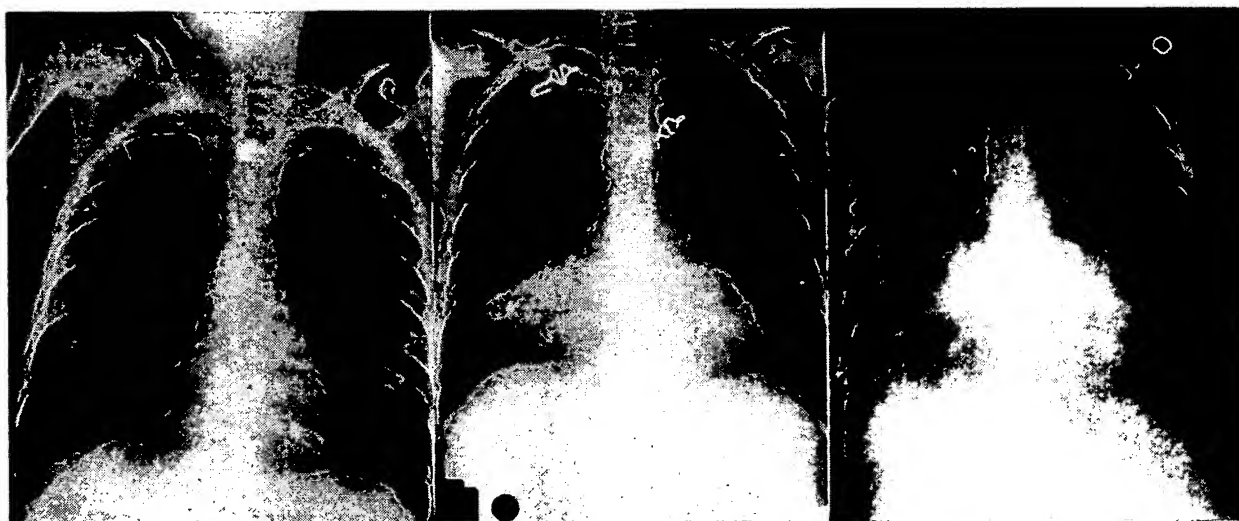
Chest roentgenograms taken on admission (1A, left), at the time pericarditis became evident (1B, center), and shortly before death (1C, right). Note progressive increase in RML infiltrate and cardiac silhouette caused by invasive aspergillosis.
